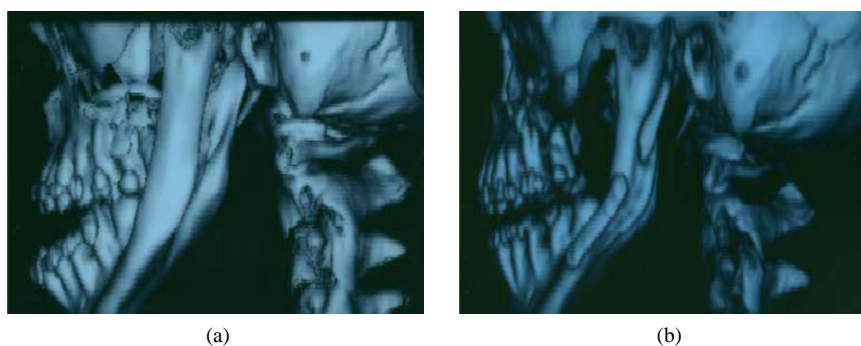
(a) Preoperative CT shows thinning of the maxillary jaw and very thin form of the mandibular ramus; (b) Postoperative CT shows improved craniofacial morphology.
